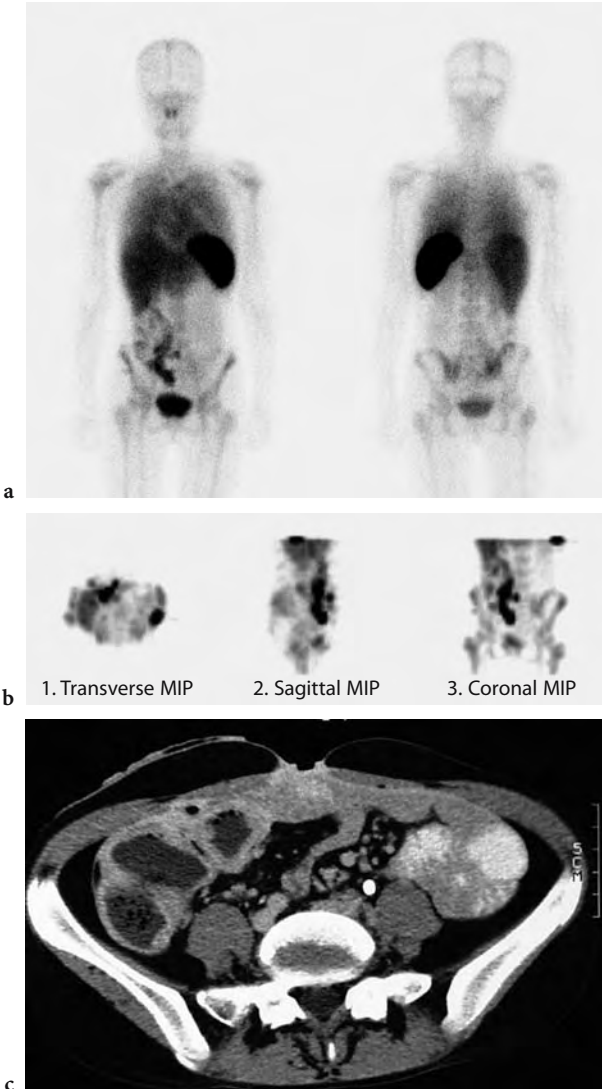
16 year old female with inflammatory bowel disease and previous partial colectomy with stoma in right iliac fossa and a fistulous skin tract in the anterior lower abdominal wall. CT showing extensive thick walled bowel in right lower quadrant (c). Surgical abdominal scar in the midline marked with a paper clip anteriorly, where the clinically identified skin fistula was noted. The CT scan does not clearly identify communication of the tract with bowel. ^{99m}Tc -HMPAO labeled-WBC scan shows extensive abnormal activity in the right lower abdomen with visualization of the transverse colon. There is abnormal activity to the anterior abdominal wall seen on the planar views (a) and SPECT MIP images (b). Fistulogram study showing contrast injected through a catheter placed through the skin fistula filling a connection to the colon in the right iliac fossa (d). This appearance is consistent with a colcutaneous fistula. MIP = maximum intensity projection image, see Fig. 14-1b
